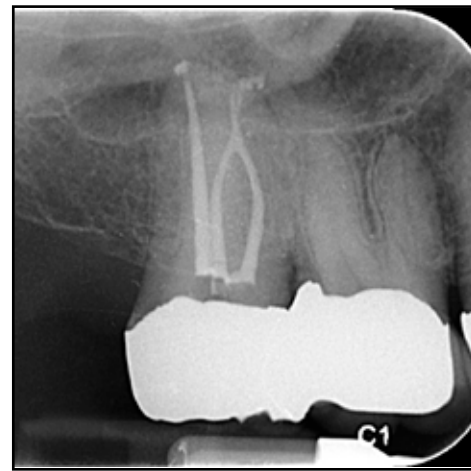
Post-operative radiograph showing that anatomy shaped and filled. Having the volumetric imaging beforehand informed the requirements for successful treatment.
